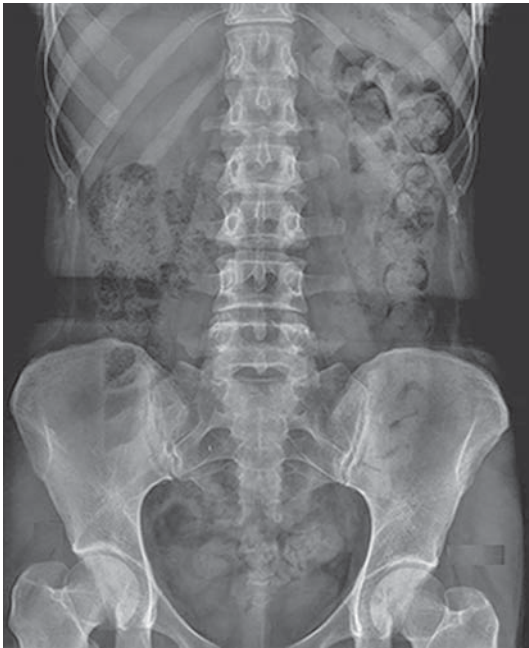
Normal anteroposterior abdominal plain film.
